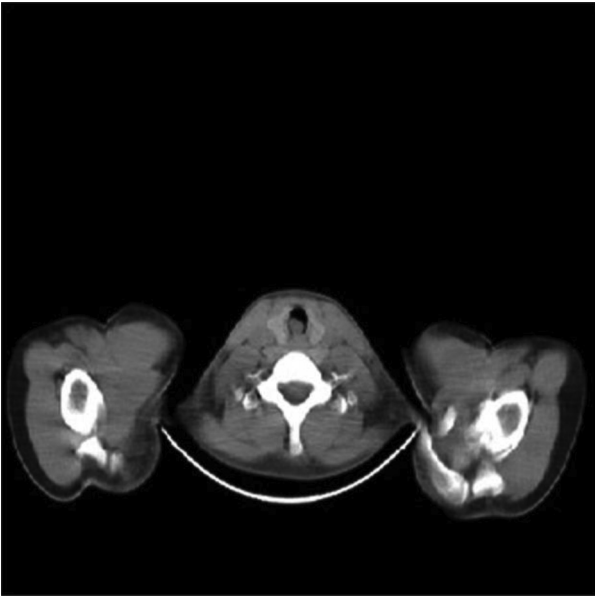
Chest CT image of the mass lesion which was obliterating tracheal lumen.
